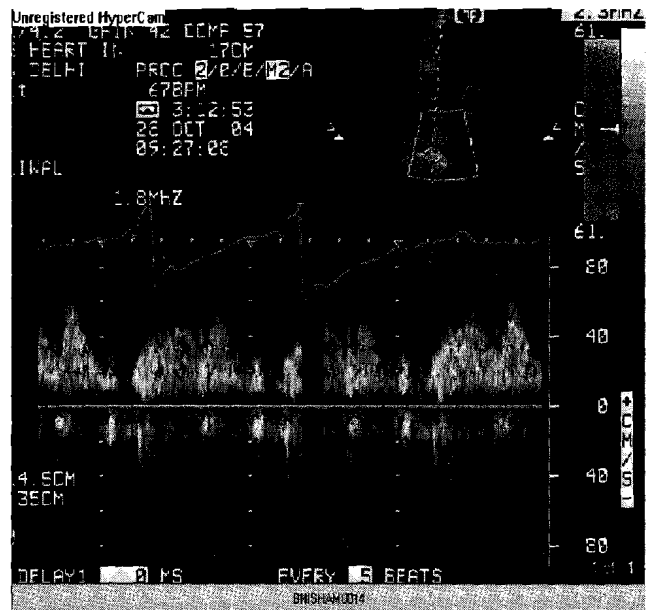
(b): Pulse wave Doppler across pulmonary vein
